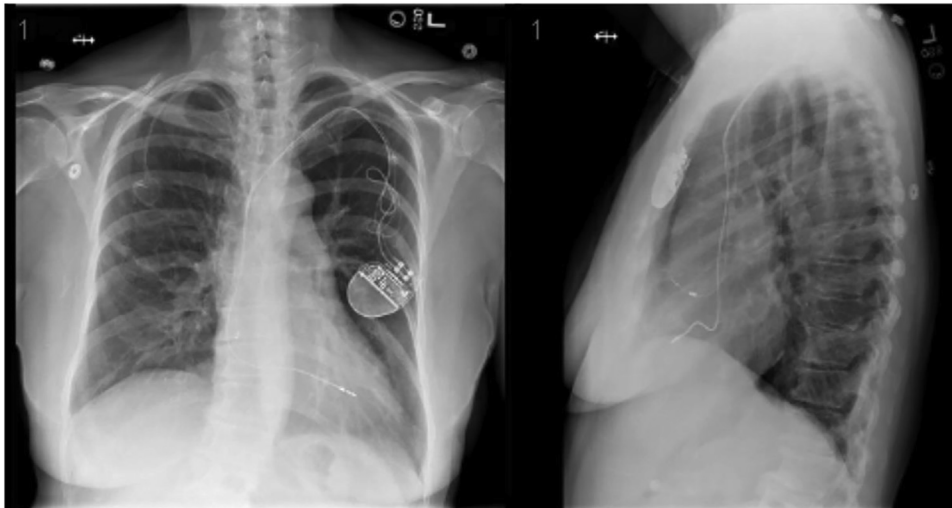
Chest radiograph revealing appropriate dual-chamber pacemaker lead position without radiographic evidence of lead fracture.
